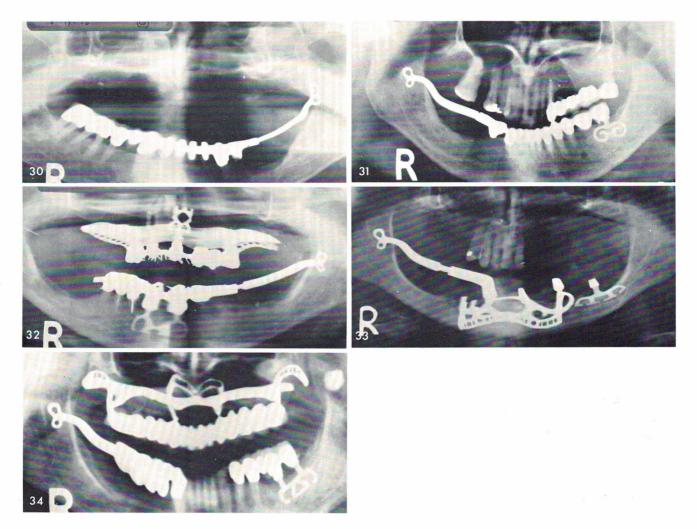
shows x-rays of other bilateral sliding cables.
